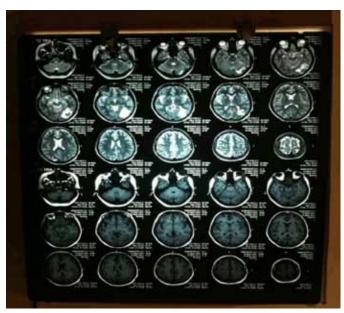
Magnetic resonance imaging scan of brain showing multiple areas of hemorrhages in left lobe of cerebellum, parietal and occipital lobes.
